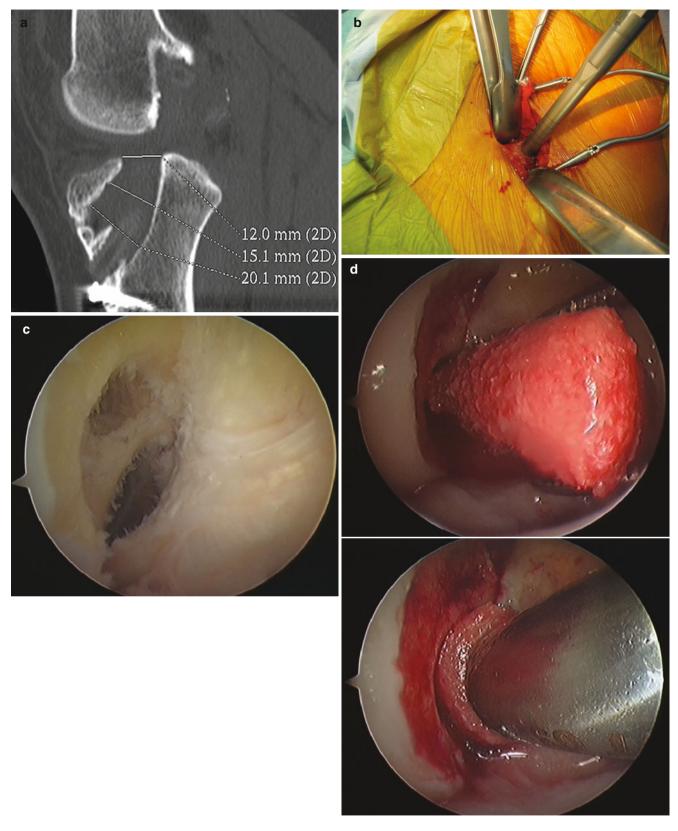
(a) Sagittal CT image demonstrating tunnel enlargement and coalescence following a double-bundle reconstruction. A two-stage reconstruction is indicated. (b) Iliac crest bone harvest. (c) Debridement
